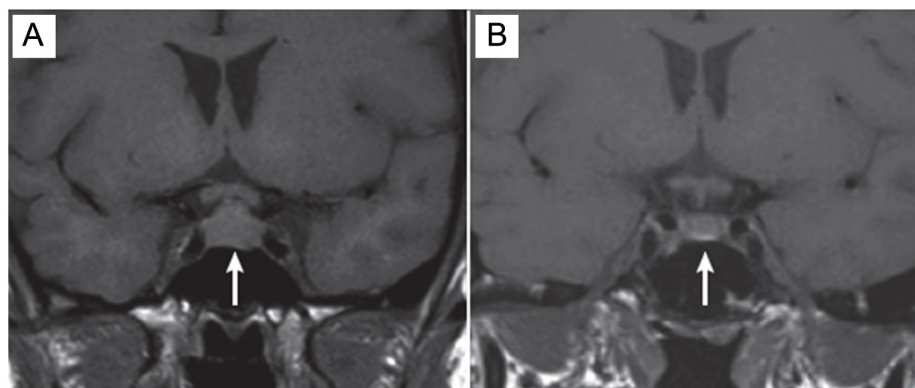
Enlargement of the pituitary gland during pregnancy. Coronal magnetic resonance imaging scans depict the pituitary gland (arrows) of a pregnant woman in the third trimester, and (A) 6 months after delivery (B) Adapted from reference.³
